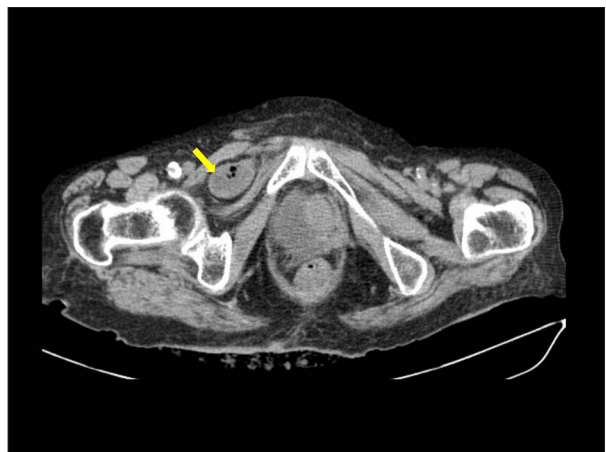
Axial view on an abdominal computed tomography scan showing incarcerated small bowel in the right obturator hernia (yellow arrow).
